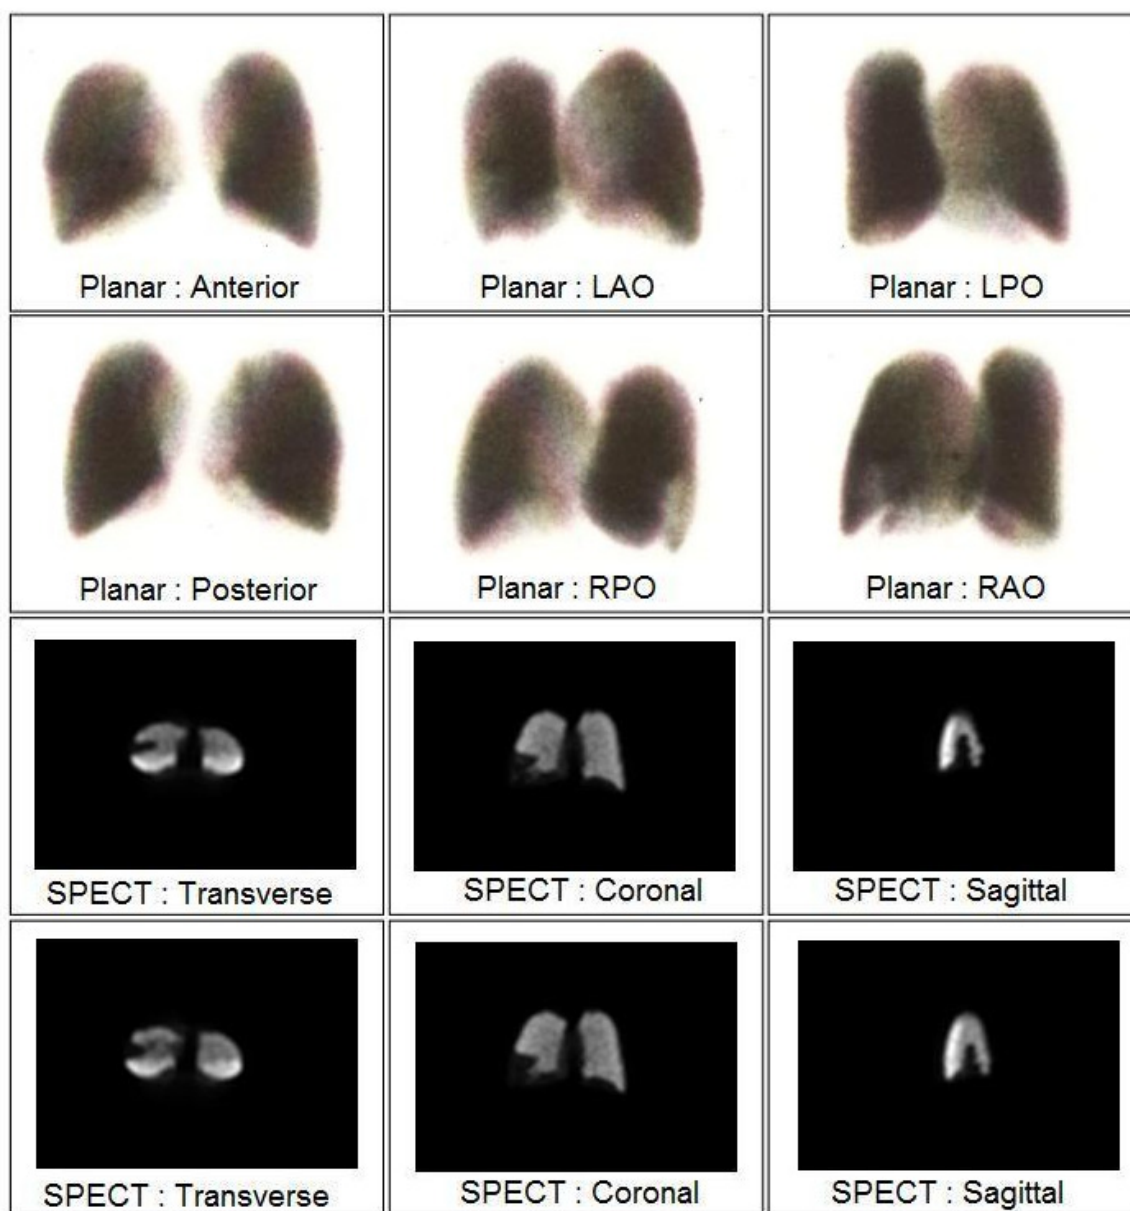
Planar and SPECT images of a perfusion defect within the lateral basal segment of the right lower lobe.
